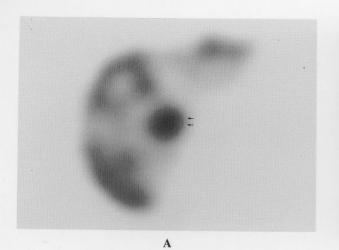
Metastatic adenocarcinoma. A. GSA shows decreased accumulation in segment IV (arrow). B. T2-weighted MR image shows hyperintensity in segment IV (white arrow).
